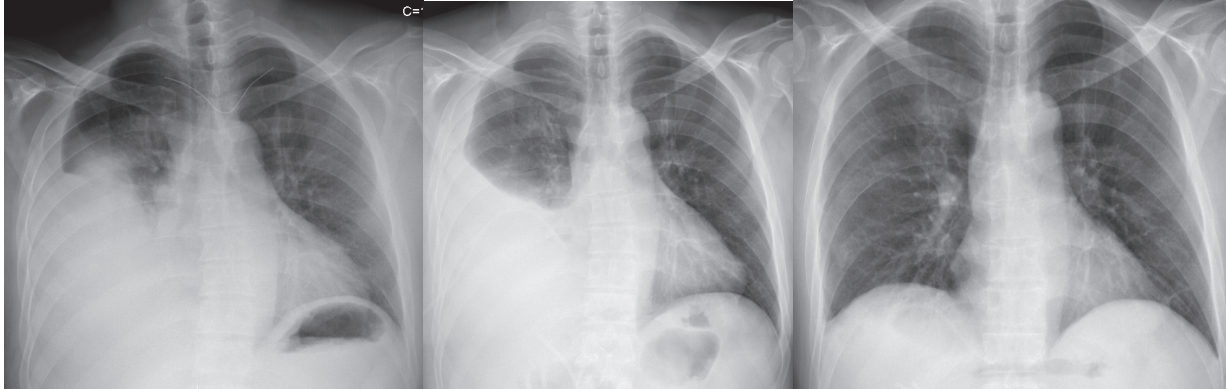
a) PA lung radiograph of the patient with parapneumonic pleural effusion; b) PA lung radiograph of the patient who could not achieve full drainage despite catheter thoracostomy; c) Post-IPFT PA lung radiograph of the same patient.
